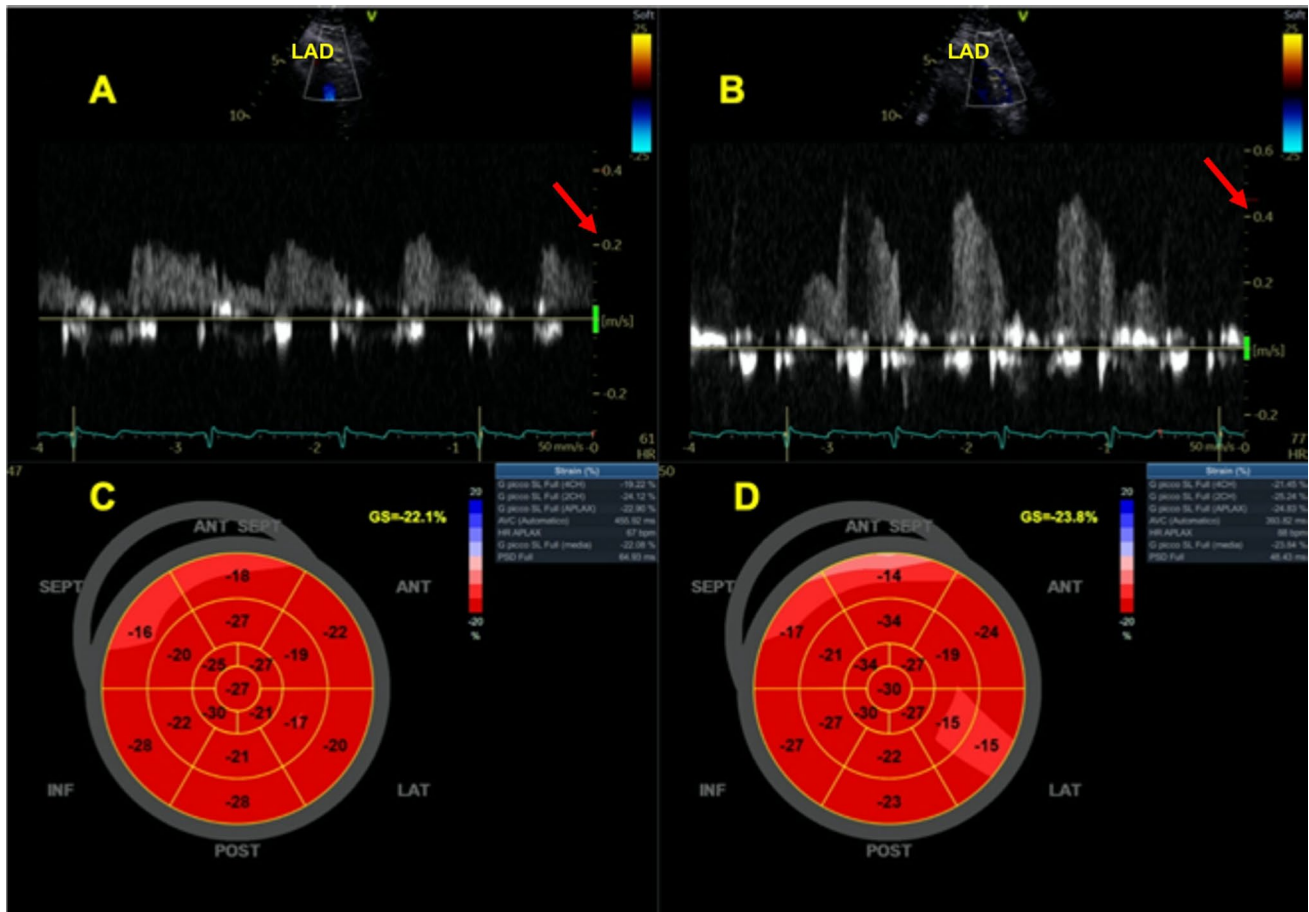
Global longitudinal strain (GLS) increase during dipyridamole stress echocardiography in a patient without coronary microvascular dysfunction. Coronary flow is sampled in the mid-distal portion of the left anterior descending (LAD) at rest (A) and at peak stress
